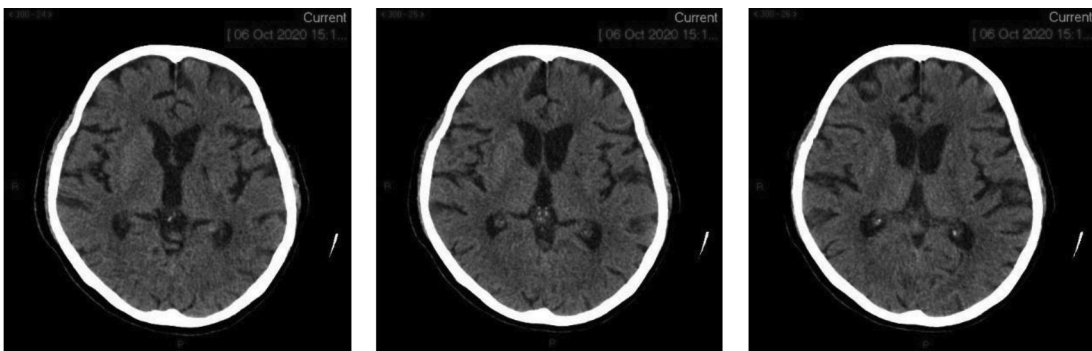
A-C Non-contrast CT scan at follow up period, 6 months after treatment
